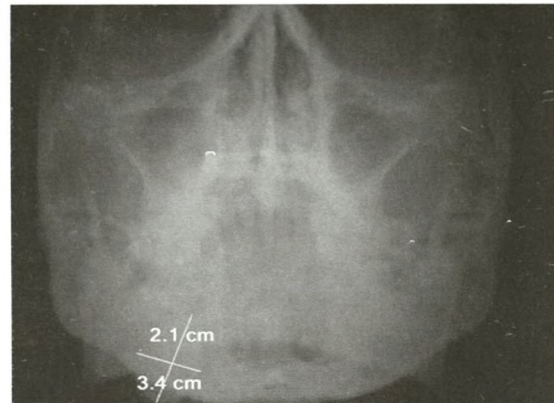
PNS radiograph showing radiopaque mass in the posterior region
